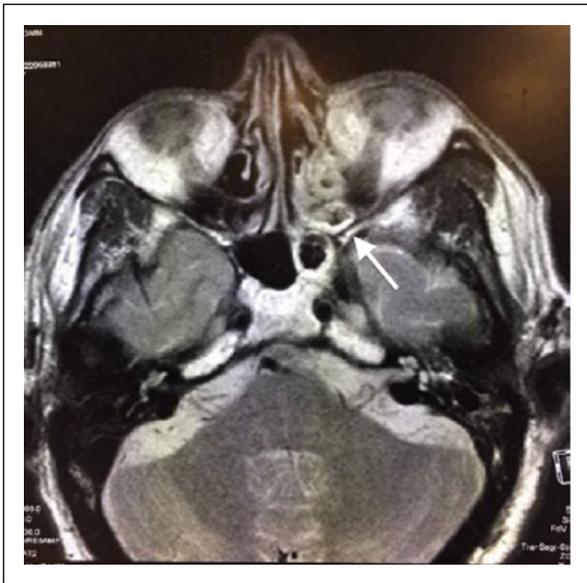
Magnetic resonance imaging T2-weighted axial view showing increased signal intensities at the left ethmoid sinus suggestive of mucosal thickening with possible extension into the left orbit.
